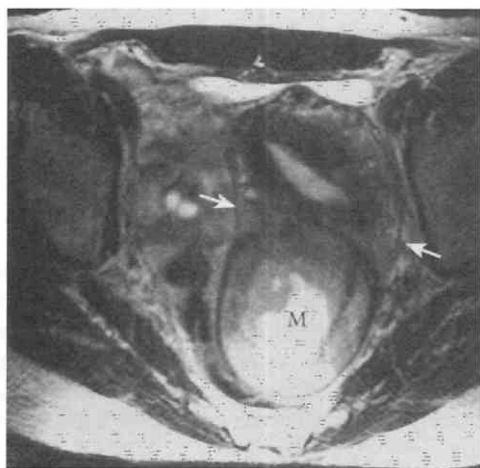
Uterine sarcoma. Axial T2-weighted, fast spin-echo multicoil image demonstrates heterogeneous intermediate signal intensity and a mass (M) arising from the posterior uterine wall. Continuity of the mass within the myometrium can be seen (arrows). The mass has internal necrosis, and no part of it displays the usual low-signal-intensity areas of a uterine leiomyoma. Pathologic examination showed an endometrial stromal sarcoma.
